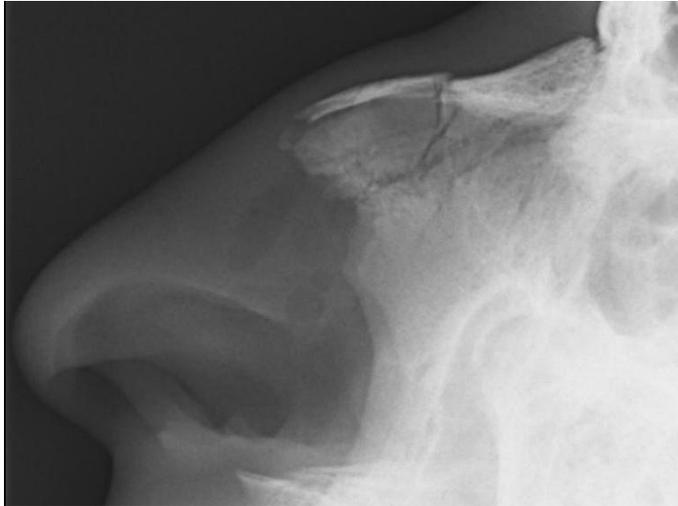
Fracture of the nose at X-ray ("File:Medical X-Ray imaging NJR06 Nevit nasal bone fracture.jpg" by Medical_X-Ray_imaging_NJR06_nevit.jpg: Nevit Dilmen (talk) derivative work: Nevit is licensed under CC BY-SA 3.0; freely available from <https://search.creativecommons.org>; not modified)
